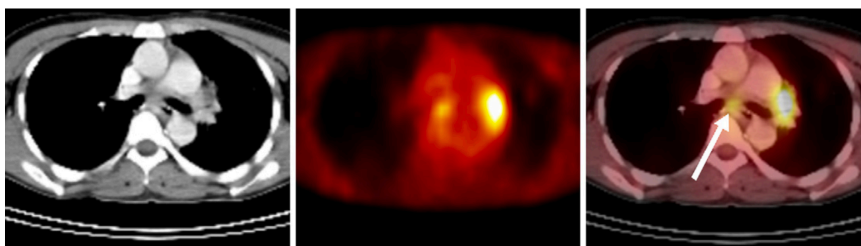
CT (left), FDG-PET (middle) and FDG-PET / CT (right) images of a patient diagnosed with NSCLC [19]
